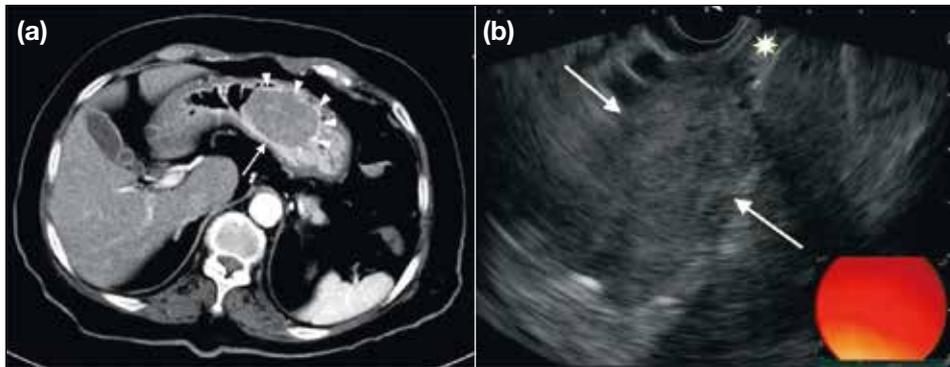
Gastric gastrointestinal stromal tumour in an 86-year-old woman. (a) Contrast-enhanced computed tomography showing a well-defined submucosal gastric mass (arrow) with smooth overlying mucosa (arrowheads). (b) On endoscopic ultrasound, the tumour (arrows) originates from the muscularis propria (asterisk).
